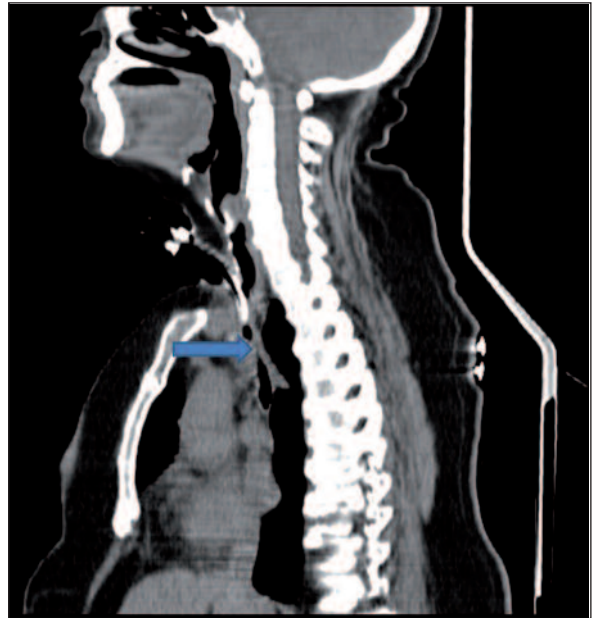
Computed tomography image of stenosis located at the front wall of the trachea below the tracheotomy line (blue line).
